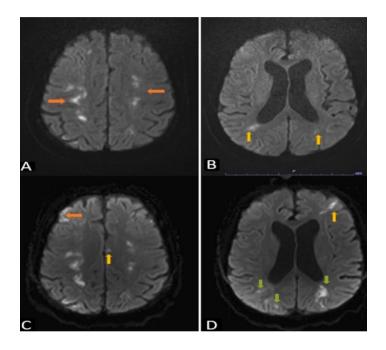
Brain MRI at admission and at day 14 of hospitalization.
